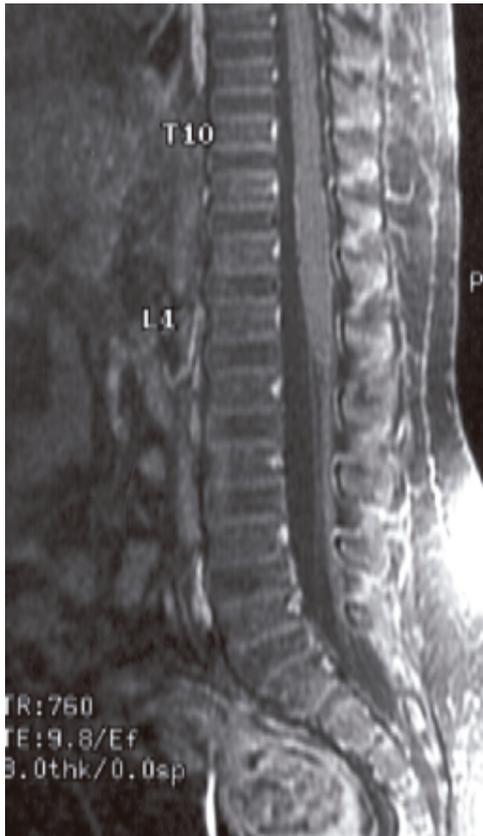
Follow-up enhanced sagittal T1-W MR image (TR760/TE9.8) taken 7 months after prednisolone treatment shows no abnormal enhancement of lumbosacral nerve roots.
